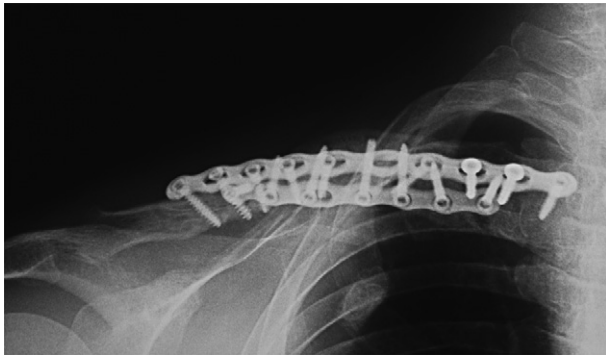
Radiographs of the final fixation construct during the fourth surgery. The clavicle was bowed upward to decompress the thoracic outlet. The resulting 2.5-cm gap in the clavicle was spanned with intercalary and on-lay iliac crest bone grafts.
